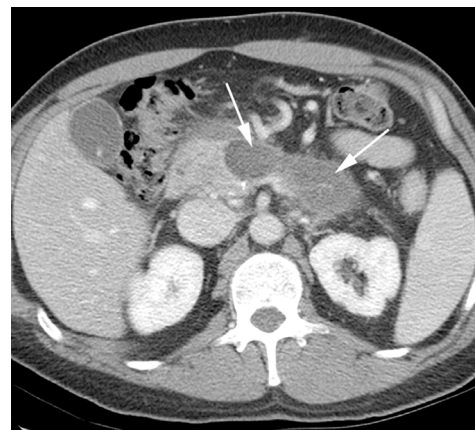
Frank's CT Scan
